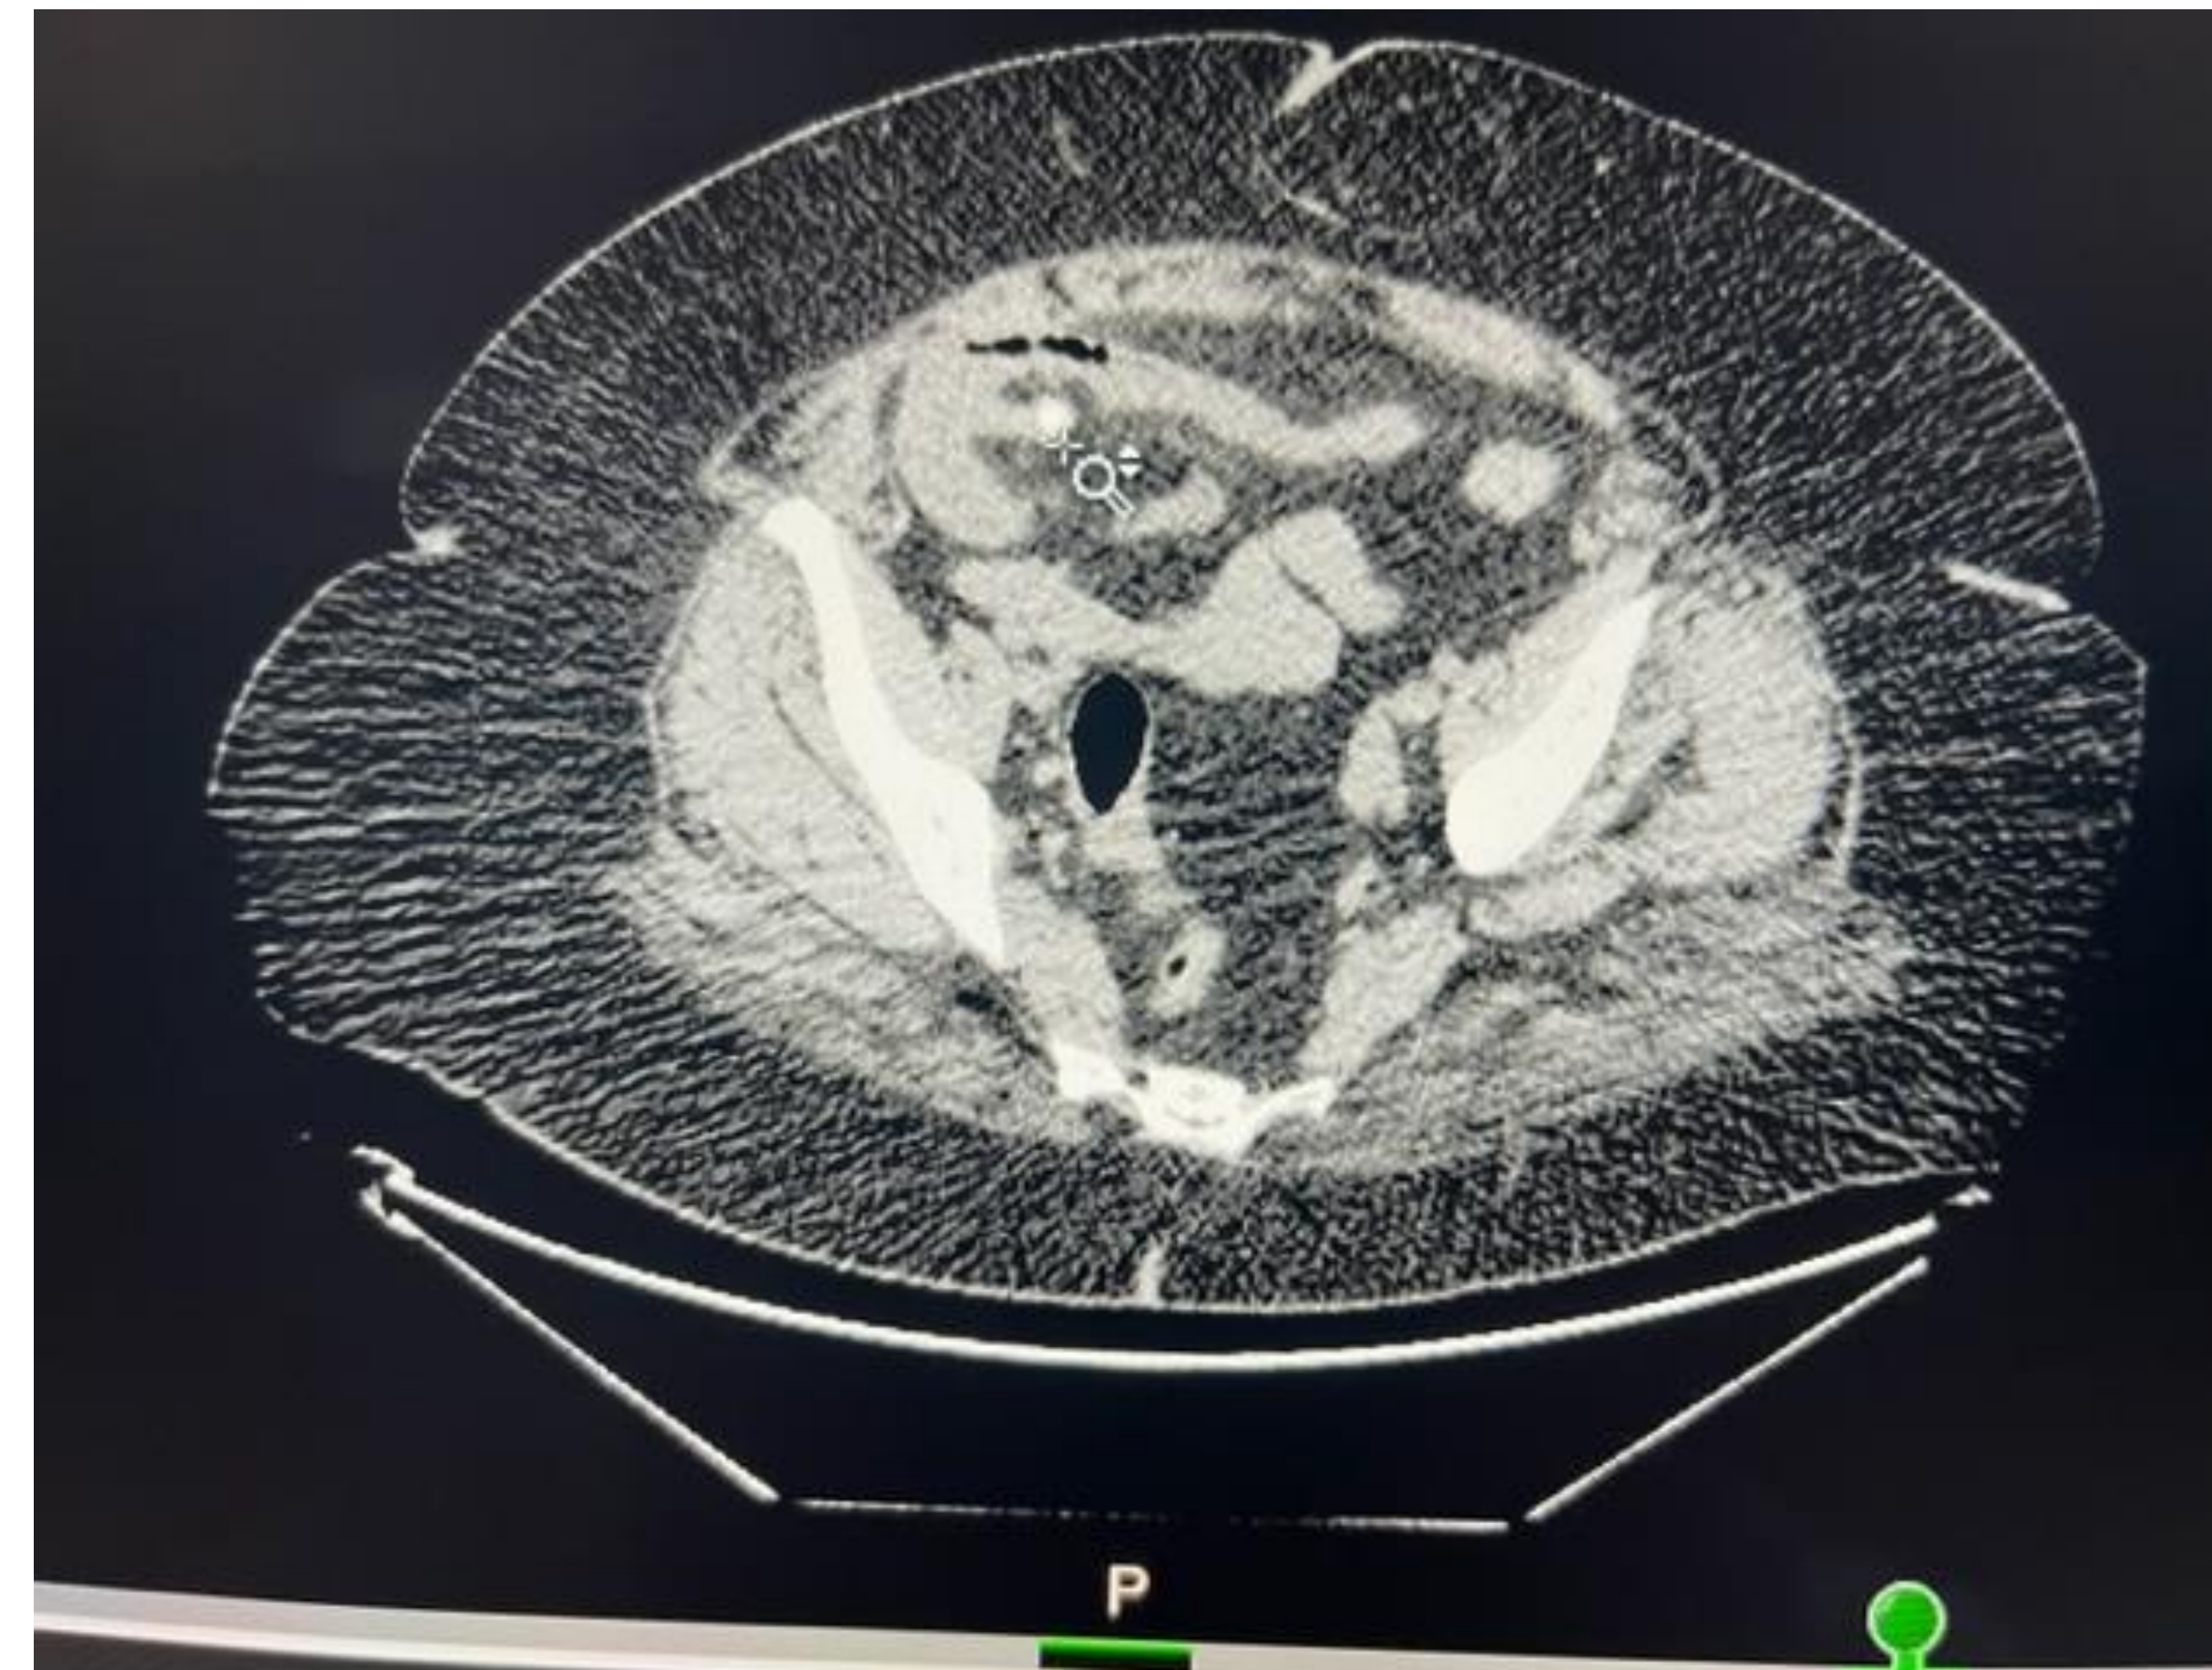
CT scan, axial view. Index marker identifies the Meckel's Diverticulum with calcification
